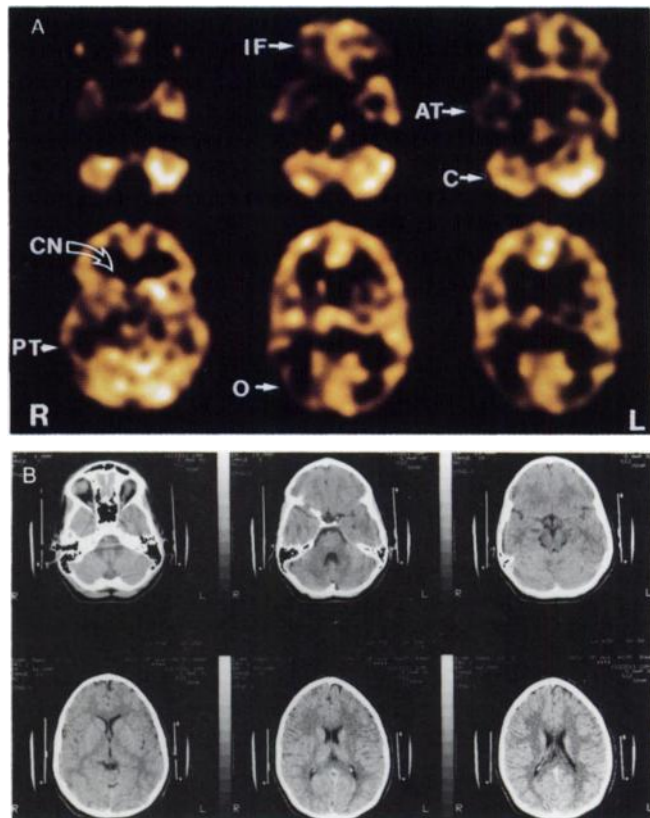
(A) Abnormal ^{99m}Tc-HMPAO brain SPECT scan of Patient 2 shows asymmetric and low tracer uptake by the right inferior frontal region (IF), the inferior and superior anterior temporal regions (AT), the right cerebellar hemisphere (C), the right caudate nucleus (CN), the posterior temporal region (PT) and the right occipital lobe (O). (B) Normal CT scan of Patient 2. The six CT sections are at the same orientation and level as the corresponding SPECT slices.
